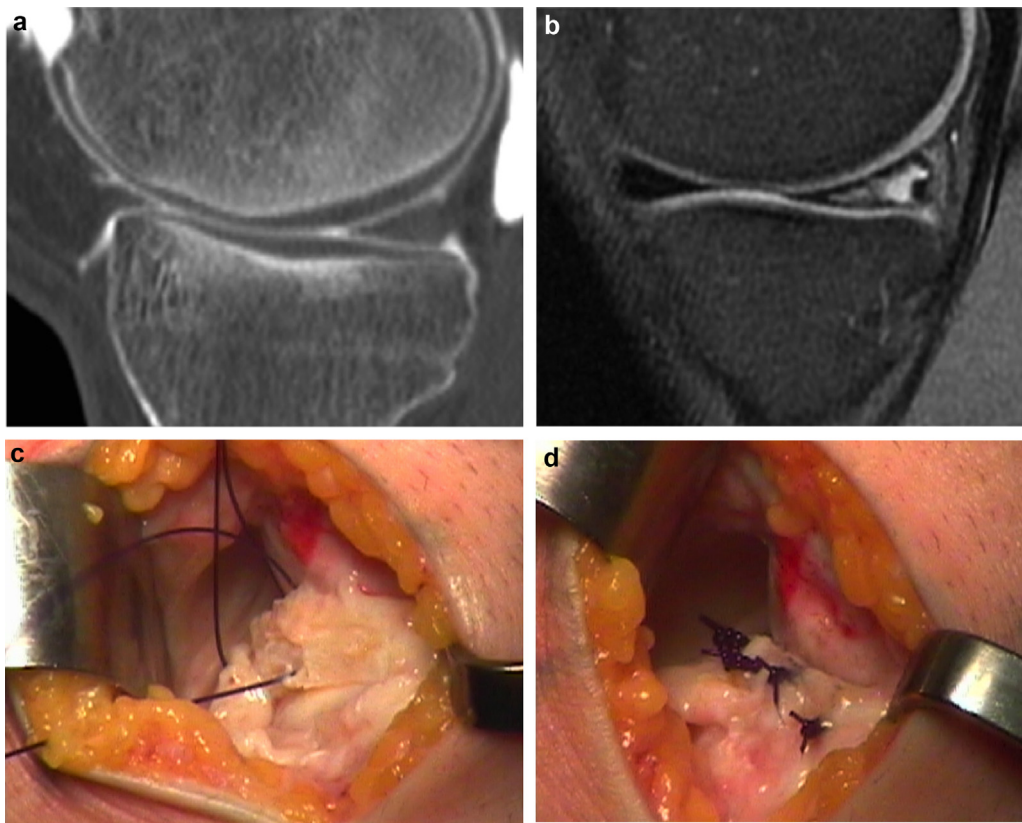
Horizontal cleavage in young athlete (medial meniscus). a: CT scan and (b) MRI of same knee at same time. CT shows normal meniscus aspect, while MRI shows extensive grade-2 hypersignal; c: open posteromedial repair; cleavage closed by vertical non-absorbable suture (PDS 0, Ethicon); d: final aspect after meniscosynovial junction closure.
